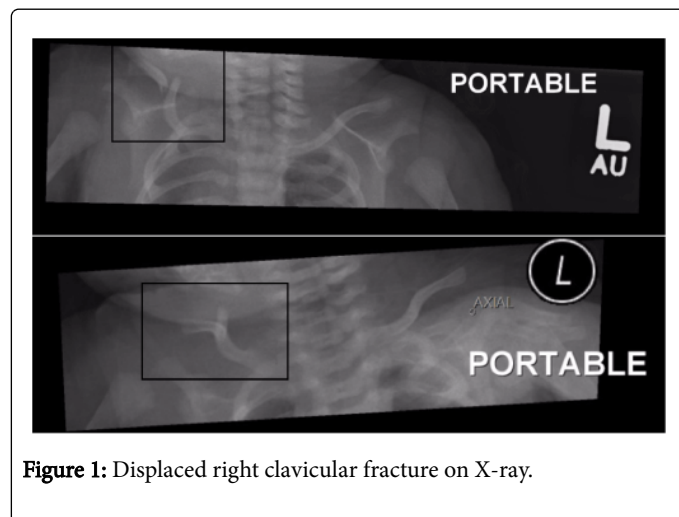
Displaced right clavicular fracture on X-ray.
